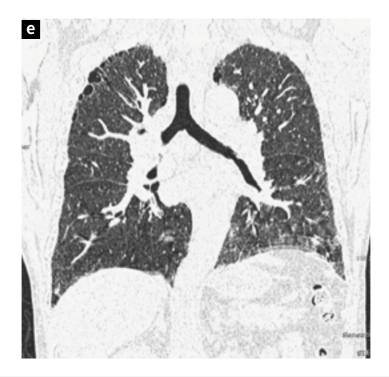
Chest radiography findings
